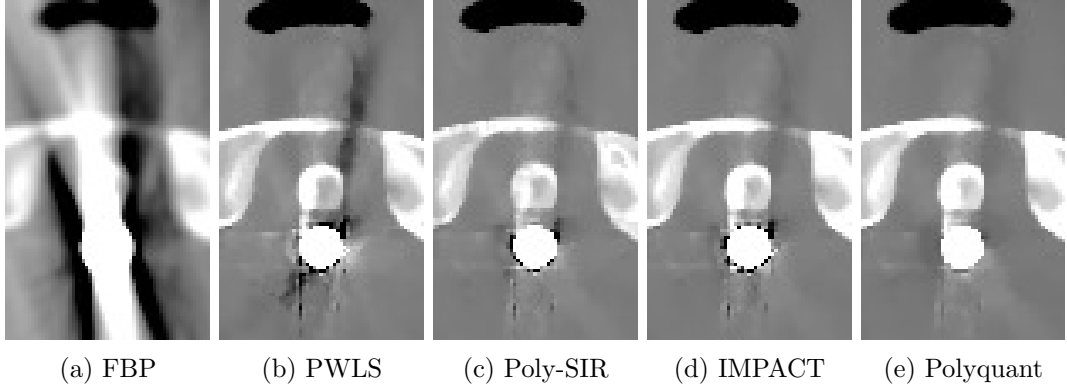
Metal insert visualisation of slice 91 from CBCT reconstructions with display window  $[0.7, 1.4]$ . The Poly-SIR is the version based upon segmentation from the PWLS as that in Figure 3.16c.
